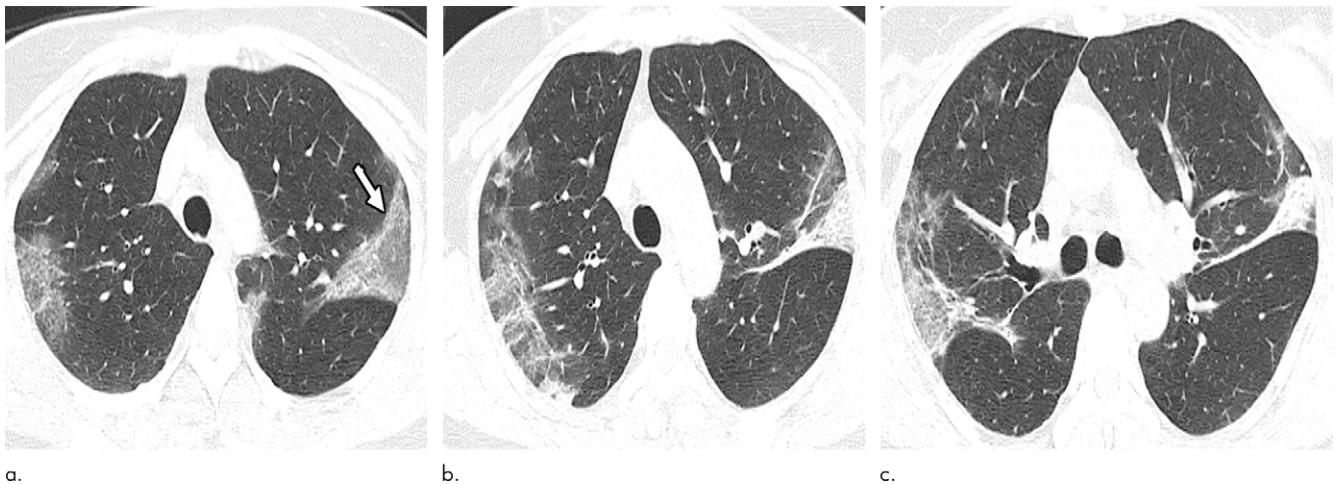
(a) Note the peripheral predominant airspace opacities with a reversed halo pattern in the left upper lobe (arrow). (b, c) Organizing changes with increasing attenuation are noted on follow-up CT images.
